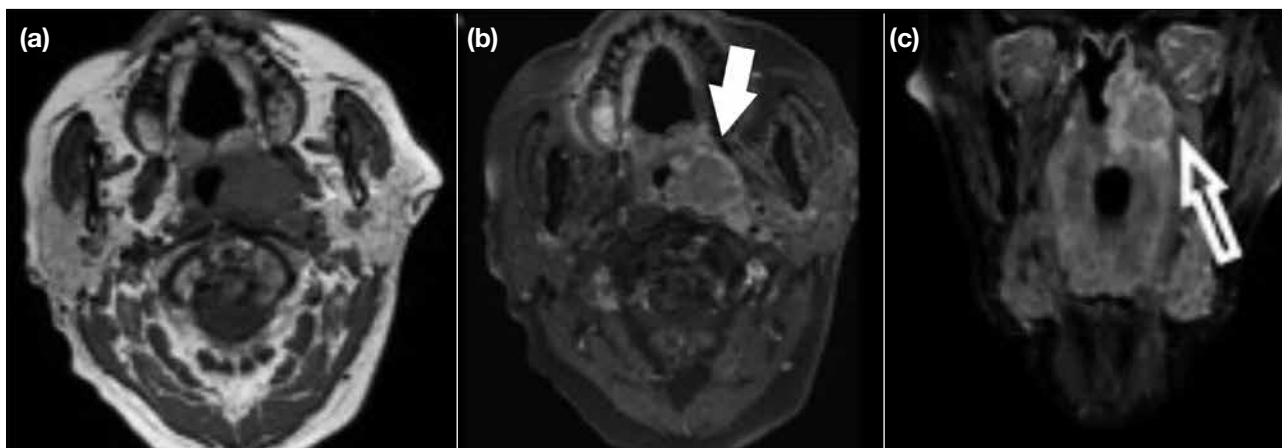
(a) Axial T1 non-contrast, (b) axial T1 post-contrast fat saturation and (c) coronal T1 post-contrast fat saturation images. Left medial pterygoid muscle is invaded by the tumour (solid arrow). There is no clearly delineated plane between the tumour and left medial pterygoid muscle (open arrow). The tumour stands out vividly in post-contrast fat saturation sequence. Magnetic resonance imaging has a high level of soft tissue contrast and enables delineation between the primary tumour and the left retropharyngeal lymph node.
